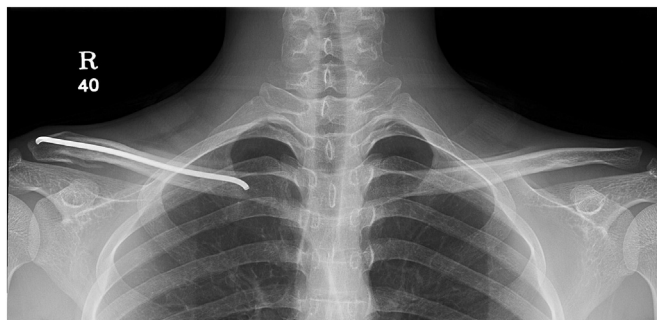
After 6 months postoperative anteroposterior radiograph of the both clavicle showing the union of the distal fracture of right clavicle.
